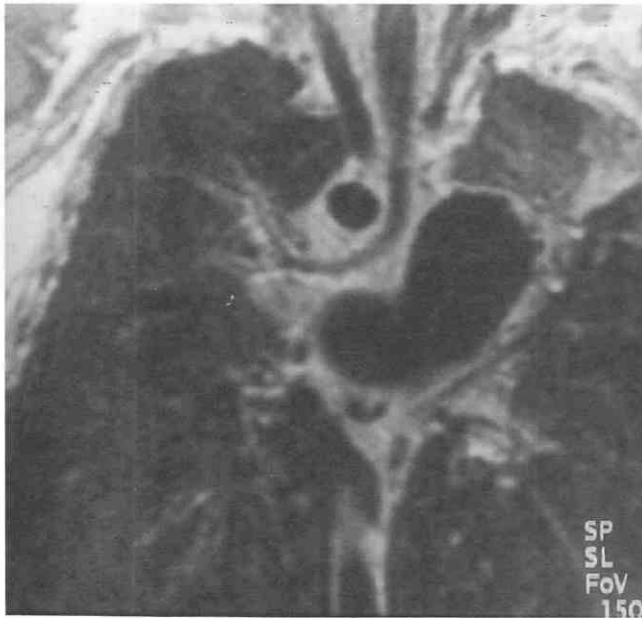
Tetralogy of Fallot and absent pulmonary valve in a 2-week-old infant. Coronal cross-sectional echocardiographic image shows aneurysmal dilatation of the pulmonary arteries and uplifting of the right main bronchus.
